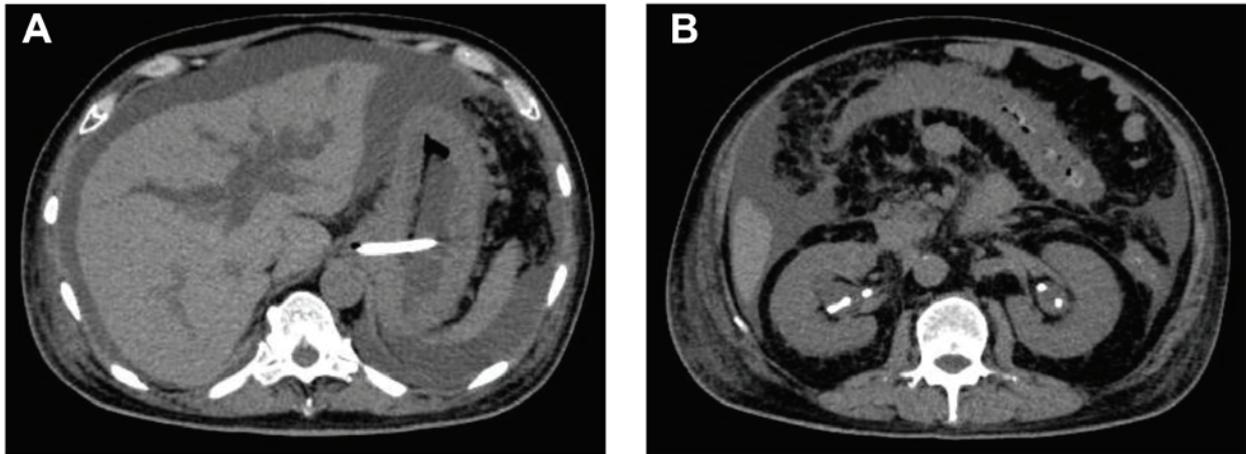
Abdominal CT scan pre-chemotherapy. CT scan image revealed gastric wall thickening, moderate ascites, intrahepatic bile duct dilation (A), and bilateral hydronephrosis (B).
